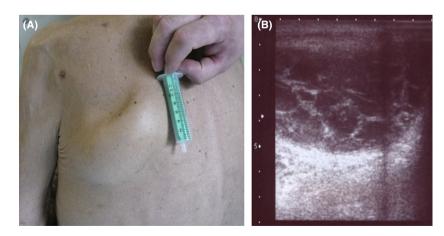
The patient's back (A) and an ultrasound image revealing a multicystic mass with fluid of low echogenicity and no evidence of increased vascularization (B).
